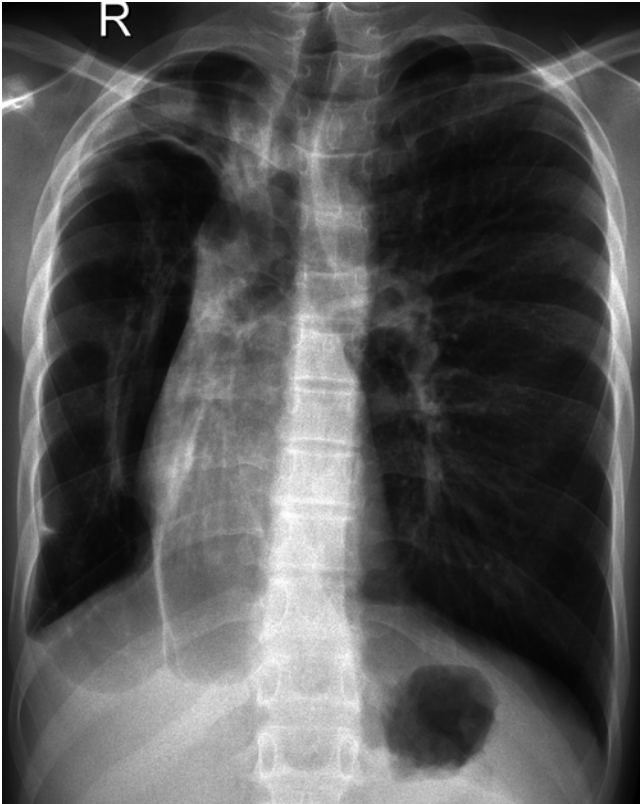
Reactivation TB. Chest radiograph of a 13-year-old boy with chronic cough and shortness of breath showing fibrotic changes, pleural thickening, and volume loss in the right lung
